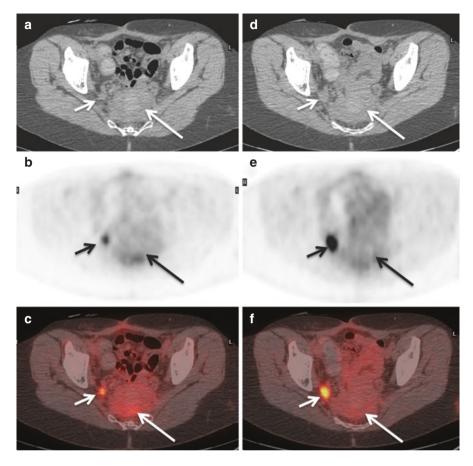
Role of FDG PET-CT in recurrent colorectal cancer. 65-year-old female with suspected recurrent colorectal cancer after long course chemoradiotherapy and low anterior resection for rectal cancer. Axial CT (a), FDG PET (middle) and fused (bottom) images of a FDG PET/CT scan. First follow up PET-CT with CT (a), attenuated corrected (b) and fused (c) images performed 6 weeks after surgery demonstrates presacral soft tissue with low intensity FDG uptake (long arrow) presumed to represent post treatment inflammatory uptake. A sub-cm right internal iliac node with intermediate intensity uptake (short arrow) is suspicious but remained indeterminate between a reactive or malignant node. Subsequent follow up FDG PET-CT with CT (d), attenuated corrected (e) and fused (f) images performed after 3 months demonstrates decrease in intensity of FDG uptake within a stable presacral soft tissue mass (long arrow) consistent with post treatment fibrosis. However, there is increase in both intensity of FDG uptake and size of the right internal iliac node (short arrow) consistent with malignant nodal uptake in keeping with recurrent nodal disease
